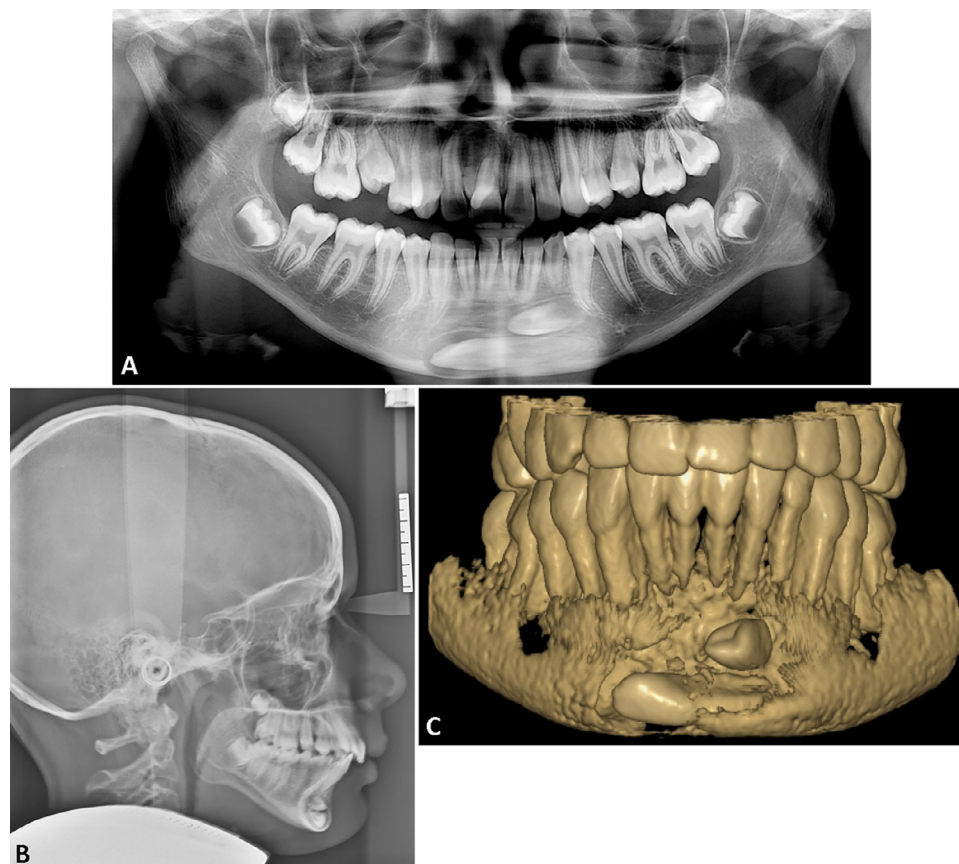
A and B, Pretreatment panoramic and lateral cephalometric radiographs; C, CBCT image.
